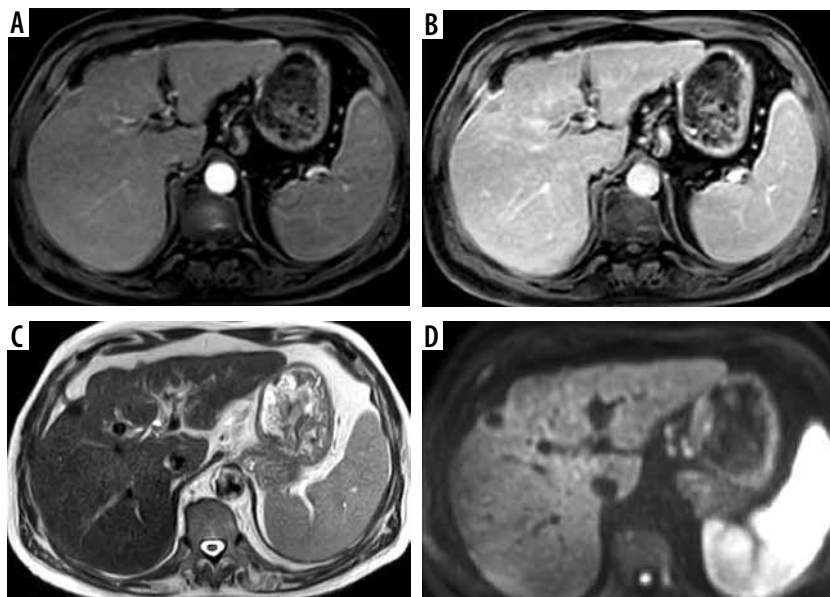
LR-2. Regenerative siderotic nodule in cirrhotic liver. A) Arterial phase shows a subcapsular hepatic focal lesion with no arterial hyperenhancement. B) Portal venous phase shows no washout or enhancing capsule. C) T2-weighted image shows a low signal hepatic lesion. D) Diffusion-weighted imaging shows no diffusion restriction in the hepatic lesion
